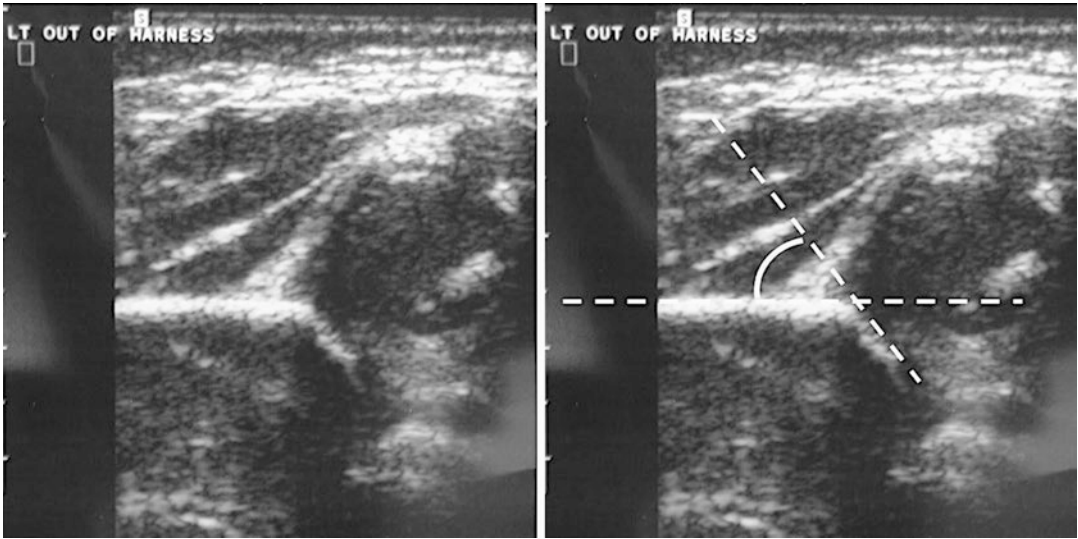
Ultrasound image demonstrating the alpha angle. The image on the left shows the view obtained when the lateral cortex of the ilium appears as a straight line. The angle measurement is shown in the image on the right
